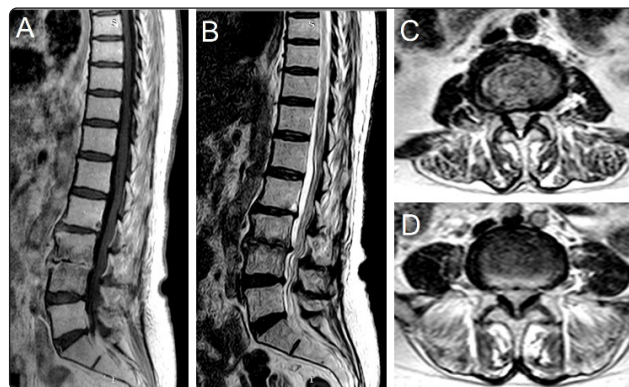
MRI of the lumbosacral spine, (A) T1 image sagittal, (B) T2 image sagittal, (C) T2 image axial L3-L4, and (D) T2 image axial L4-L5, showing the destruction of L3-L4 disc space with abnormal signal intensity at the adjacent endplate and degenerative stenosis of L4-L5 level.
